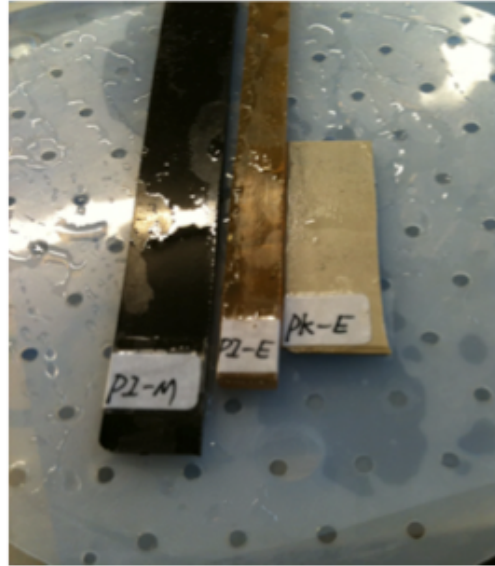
Ultrasound transparent materials for acoustic transparency testing.
